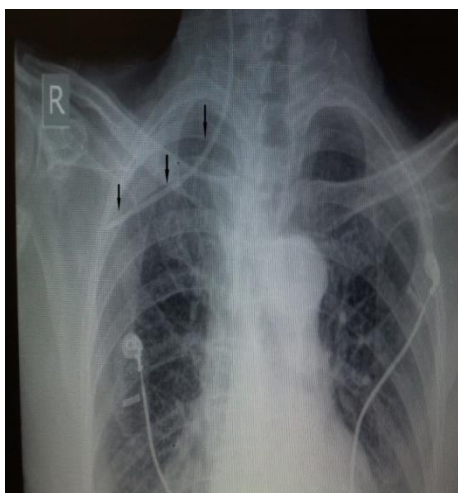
Chest X-ray on the left of the patient showing malposition of CVC (path highlighted by black arrows) from right IJV.
